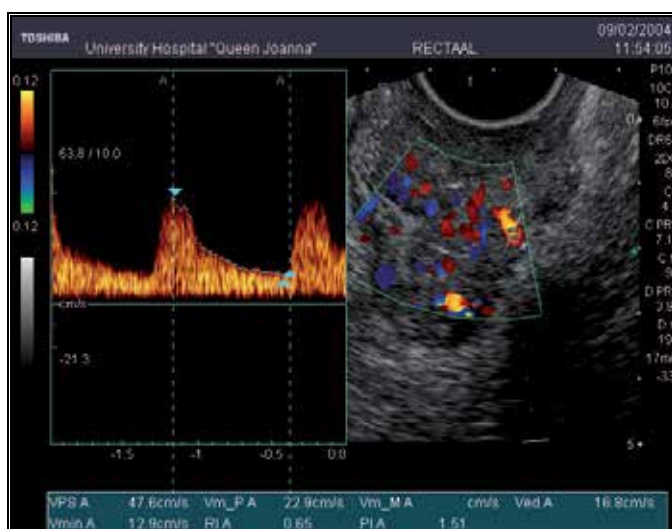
Pulse colour Doppler endosonography of rectal cancer (high PSV - 47.6 cm/s and low RI - 0.65).
